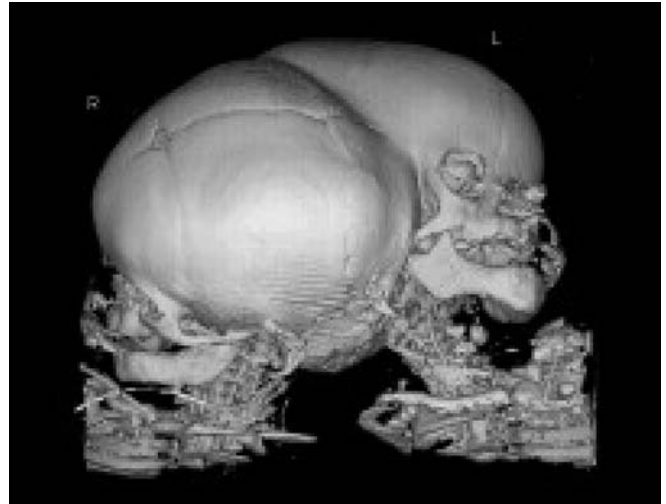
Reconstructed image from the CT scan. A shaded surface 3D technique using a bone algorithm. The skulls are deformed and fused in both parieto-occipital regions. *R* right twin, *L* left twin
